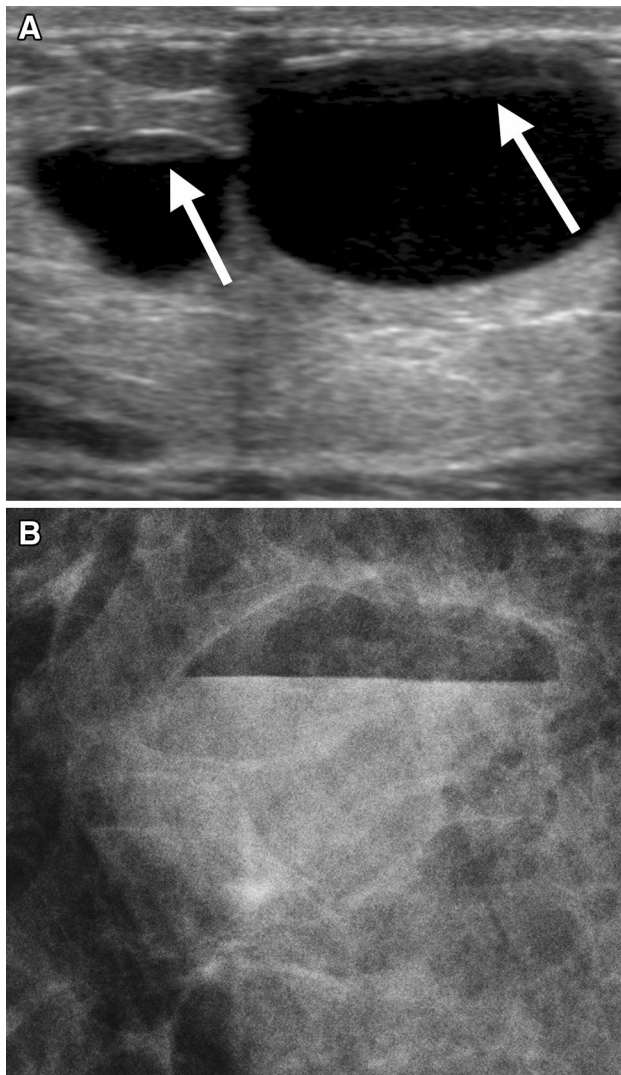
A 40-year-old lactating female with a palpable right breast lump. a Targeted ultrasound demonstrates two adjacent cysts with fat-fluid levels. b Spot compression mammography at the palpable site also demonstrates a fat-fluid level. Findings are compatible with benign galactocele
